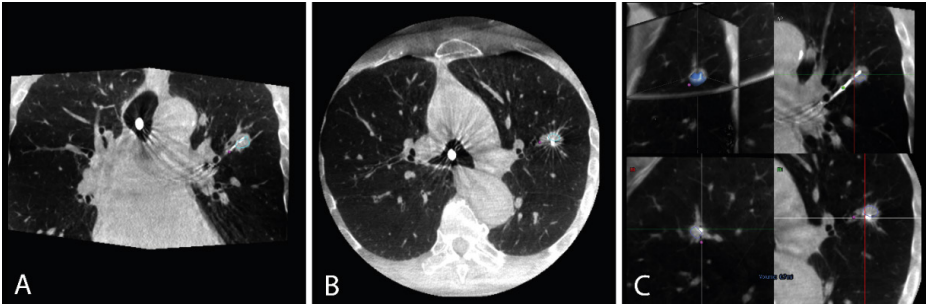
Visualization of the Pioneer Plus catheter on CBCT imaging in the transversal plane (A), coronal plane (B), and adjusted planes (C). The needle visibly protrudes into the lesion in (A) and (C, lower right) at the ten o'clock position of the radial US-transducer. An intratumoral injection was performed here. CBCT, cone-beam computed tomography; US, ultrasound.
